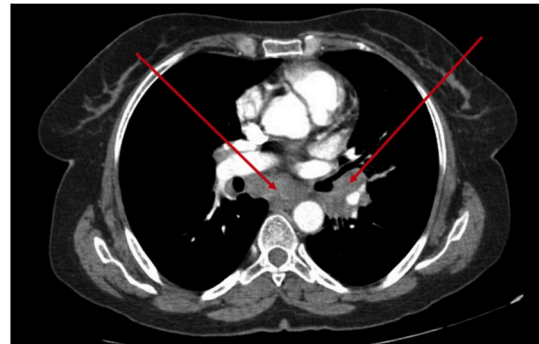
Thoracic CT scan (mediastinal window): mediastinal bilateral, asymmetric, non-compressive lymphadenopathies.
